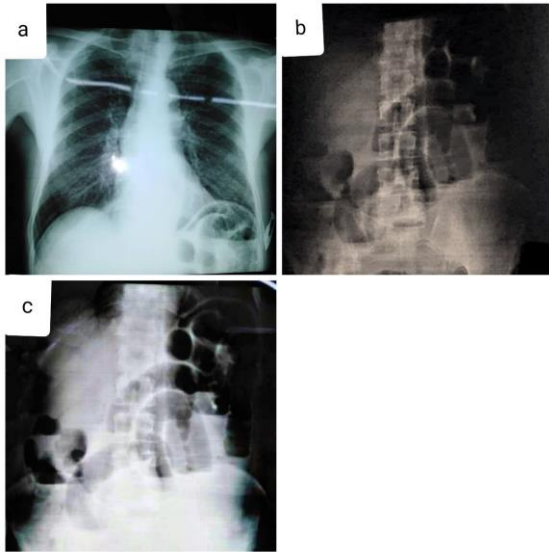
a- chest x-ray shows air-fluid levels in the stomach pouch, b-cupward abdominal x-ray shows distended bowel loops with air-fluid levels
